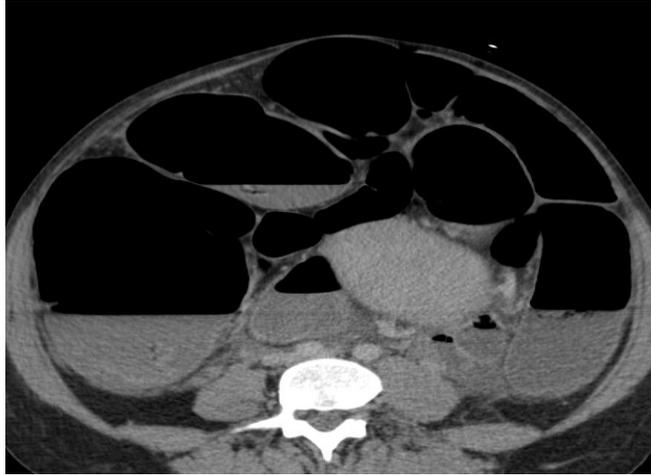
Abdominal computed tomography scan revealing massive dilation of the large and small bowel with air fluid levels.
